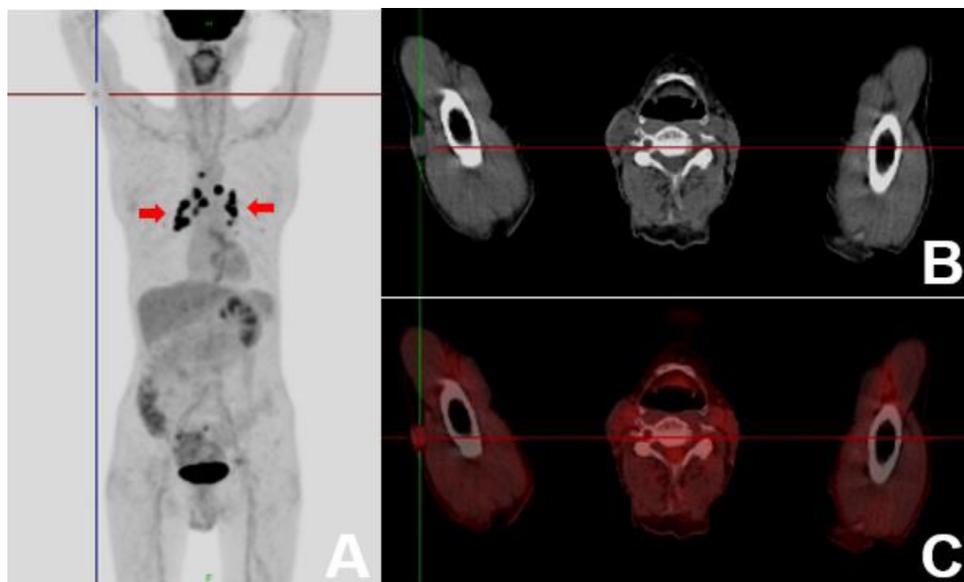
(A). The maximum intensity projection (MIP) image of the patient who had undergone post-right nephrectomy shows abnormal sites of uptake in a right arm lesion (target spot) and multiple lung nodules (red arrowheads). (B) The lesion in the subcutaneous soft tissue of right arm is noted as a low-density nodule on CT (C) with abnormal uptake on 18F-FDG PET-CT.
